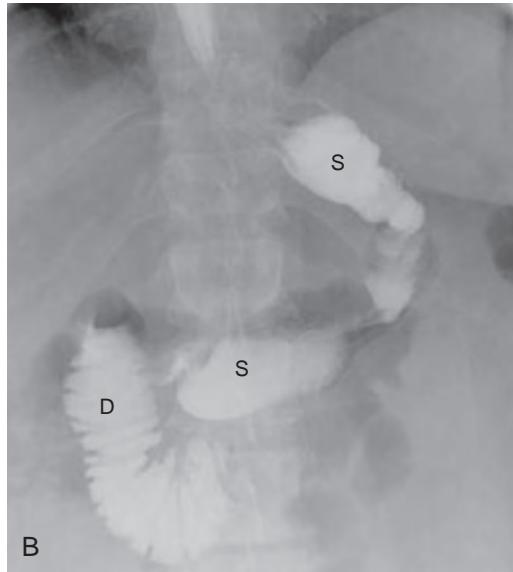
Sleeve gastrectomy. A. Gastric sleeve, with approximately 70% of the stomach resected (*shaded area*) along the greater curvature and with relative sparing of the antrum. The pylorus and duodenum are left intact. B. Supine UGI image shows the narrowed, tubular configuration of the gastric sleeve (S) in a recently postoperative patient with an intact pylorus and duodenum (D). C. Axial contrast-enhanced CT scan shows a narrowed stomach, with sutures along the resected greater curvature (*arrows*) and prominence of mesenteric fat in the expected location of the remainder of the stomach. Also note evidence of surgical injury to the left lobe of the liver.
